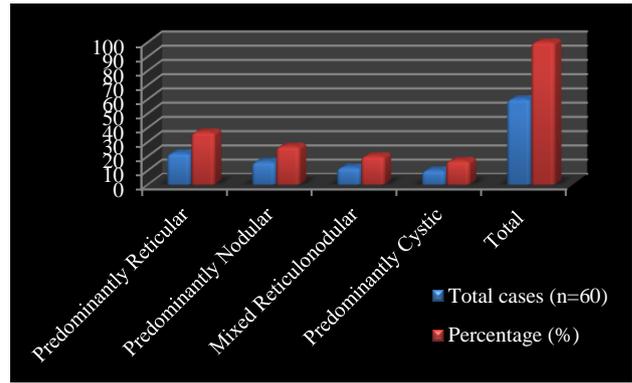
HRCT pattern based distribution of patients (N=60).
